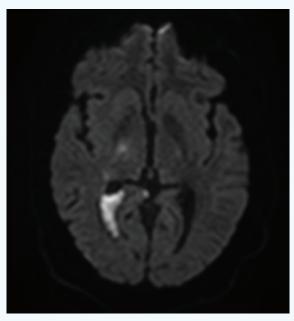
Final diffusion weighted MRI showed no new ischemic lesions after embolization.
